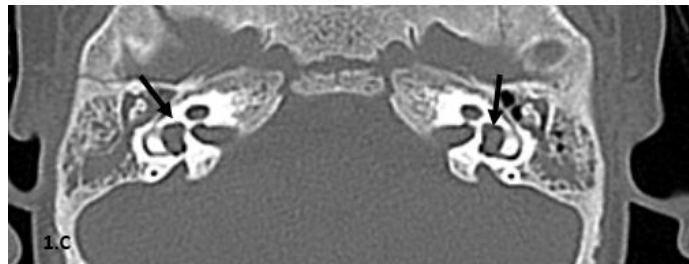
C: Axial CT bone window revealed bilaterally enlarged vestibules (black arrows).
